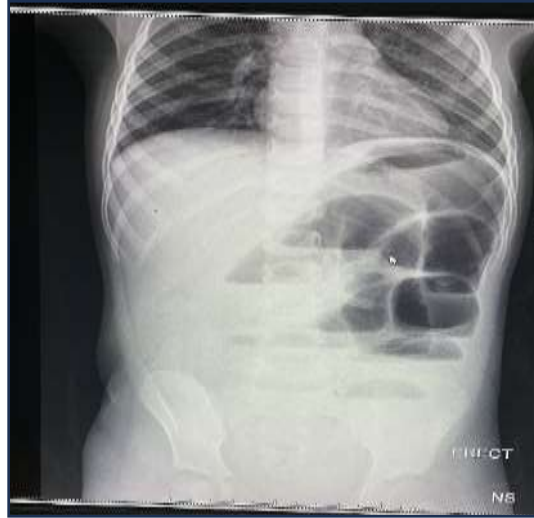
Plain Abdominal X-Ray Showing Dilated Loops of Small Bowel with Multiple Air Fluid Level and Absent Air In
